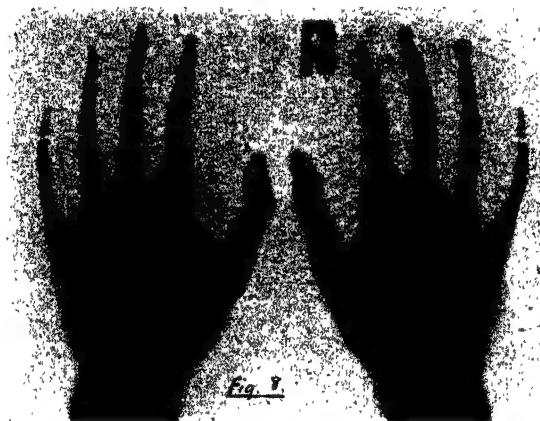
Idiopathic Steatorrhœa. X-ray of hands, showing absence of compact cortex in the bones and signs of decalcification.
